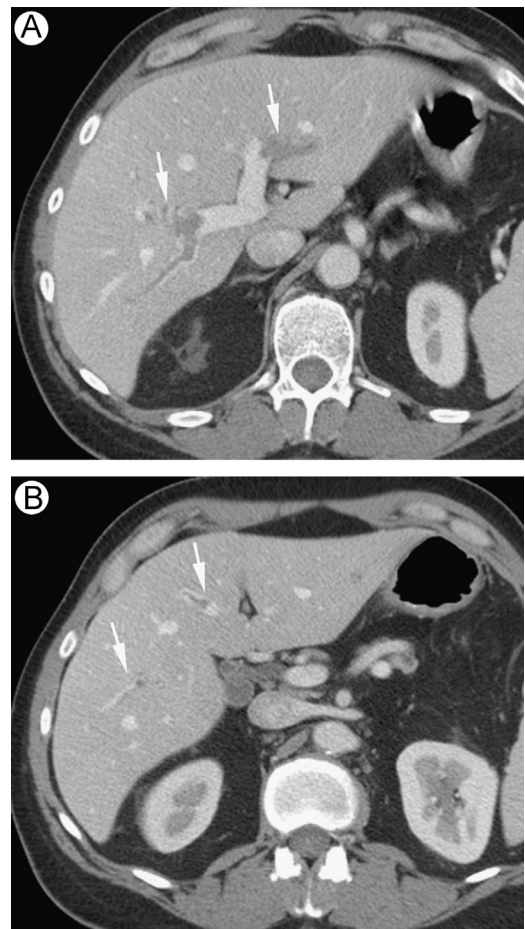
Two axial CT images (A and B) in a patient 3 weeks following IPAA show multiple portal venous thrombi in the right and left main portal branches extending distally (arrows).
